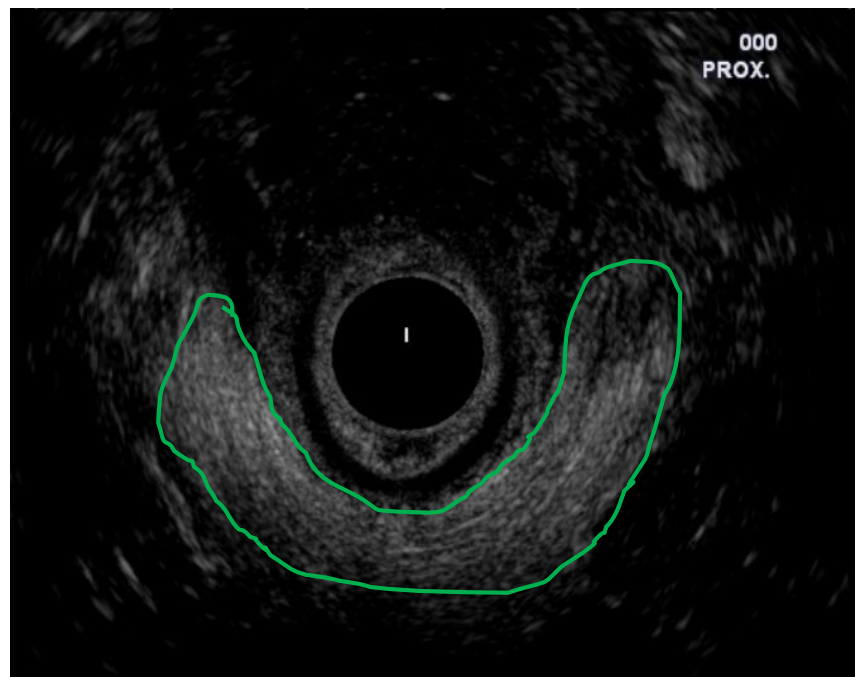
Endoanal ultrasound at upper anal canal level demonstrating normal appearances of puborectalis muscle (outlined).
